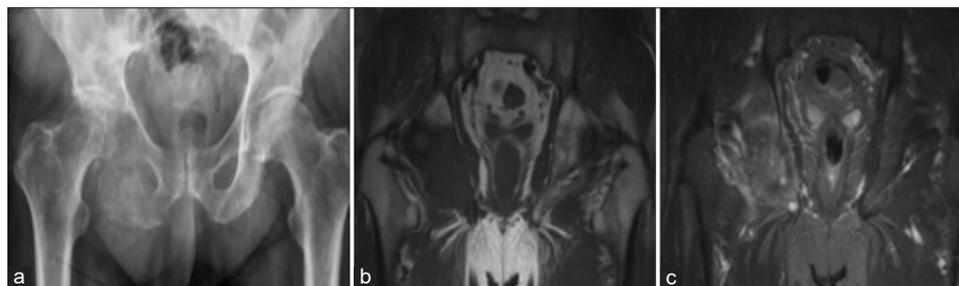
Metastasis from bronchogenic carcinoma. Radiograph (a), coronal T1 (b), and short-tau inversion recovery (c) demonstrating destructive lesion involving the right ischium.
